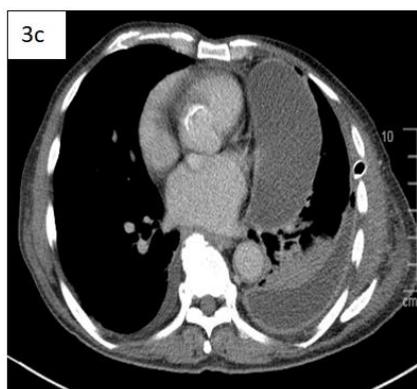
Pre operative CT thorax of the patient with left sided empyema thoracis, shows multiloculated left pleural effusion with “split pleura” sign
